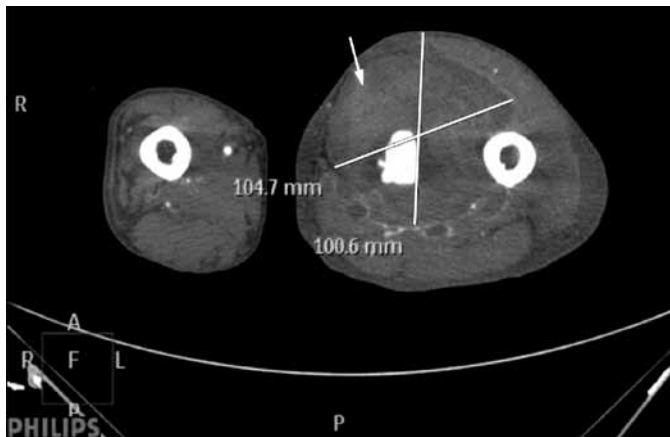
Axial CT of femur showing large haematoma around the SFA aneurysm measuring 105 x 101mm.
